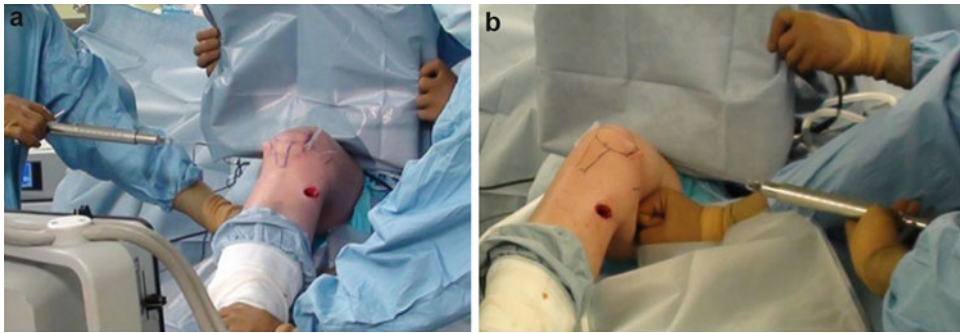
Intraoperative quantitative stress radiography of the patella. Before lateral release at surgery, a soft wire (28 gauge) was inserted into the center of the patella from the lateral side to the inside, and then, 20 N stress was
